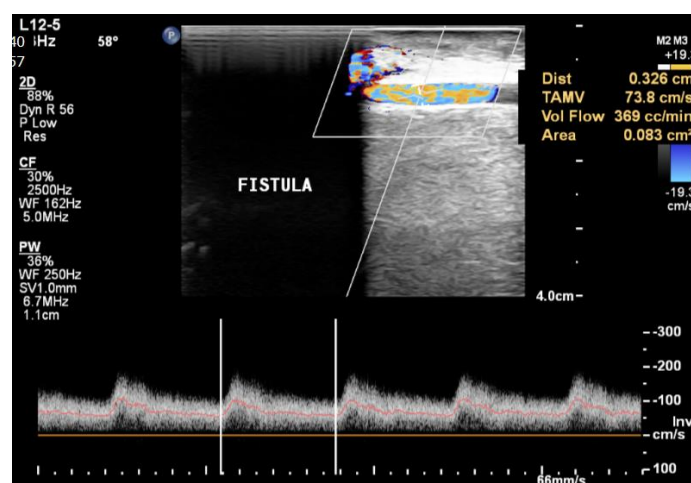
63 year old male with history of diabetes mellitus. Flow volume measurement in radial artery was done during the immediate post-operative period using colour Doppler, giving a value of 369 ml/min.
